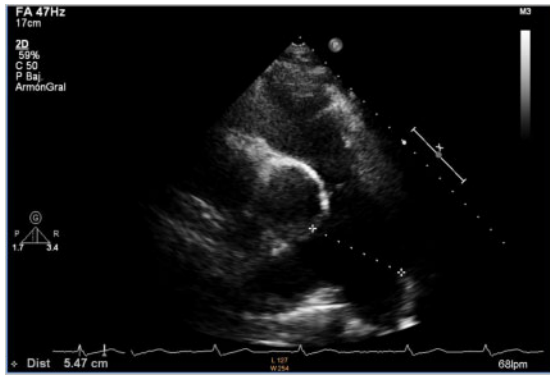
Transthoracic echocardiogram: pulmonary artery aneurysm.
